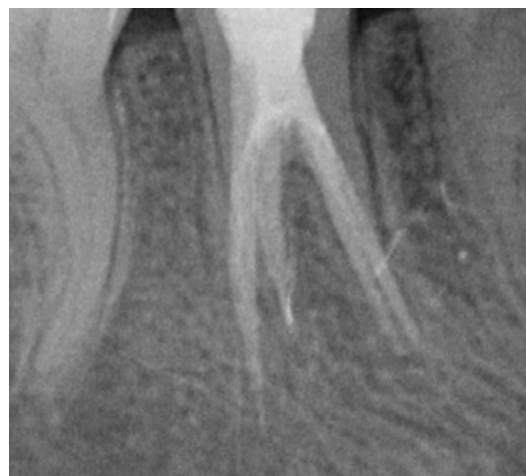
Periapical radiograph of the tooth at the session of 36th month
